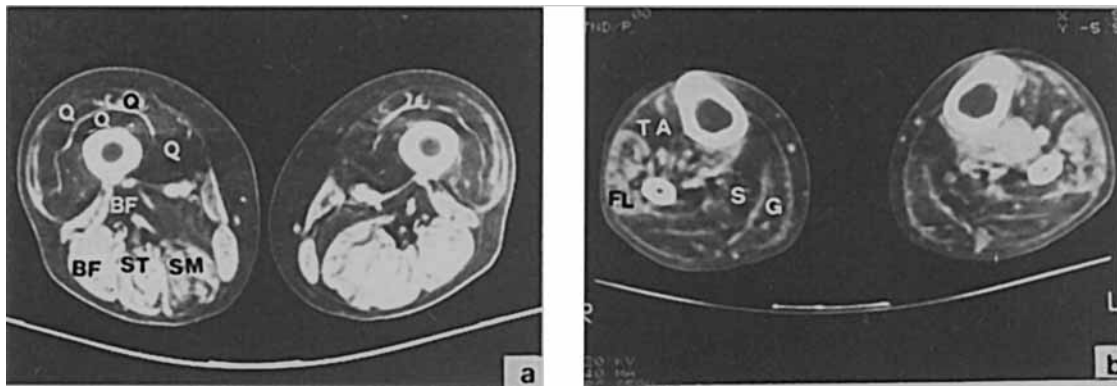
(a) Myotonic dystrophy midthigh CT scans showing an involvement of quadriceps (Q) with sparing of biceps femoris (BF), semitendinosus (ST), and semimembranosus (SM); (b) in the legs both anterior [tibialis anterior (TA)] and posterior compartments [gastrocnemius (G), soleus (S)] are affected, while peroneal muscles [fibularis longus (FL)] are spared.
